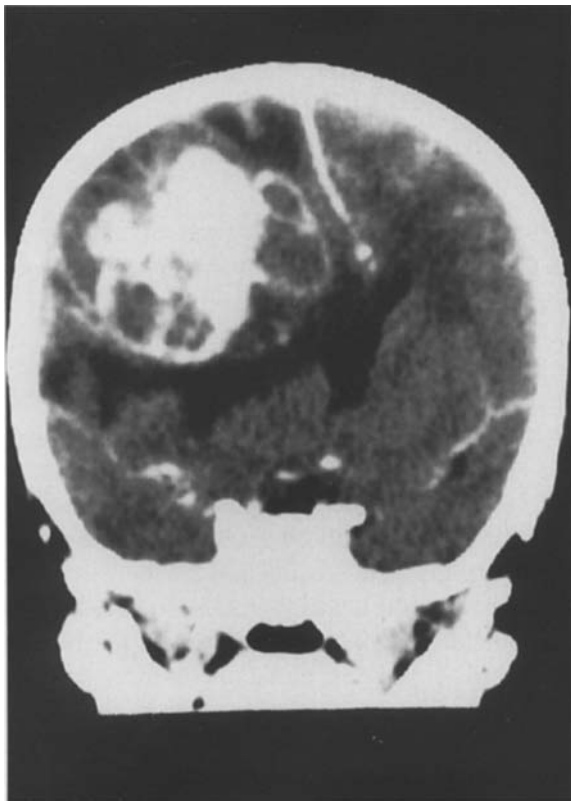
Coronal contrast enhanced CT scan in a 22 month old girl who presented with a 2 week history of vomiting and increasing lethargy. The CT scan showed features characteristic of a lobar supratentorial PNET. There is a large heterogeneous mass in the right frontal lobe, with a solid enhancing region and multiple cystic areas. There is edema surrounding the mass as well as massive shift of the midline structures. This child has a gross total removal of her lesion followed by craniospinal radiation and chemotherapy. An asymptomatic local recurrence was found 18 months after surgery and she underwent a repeat resection followed by chemotherapy. She remained well 16 months after this treatment.
